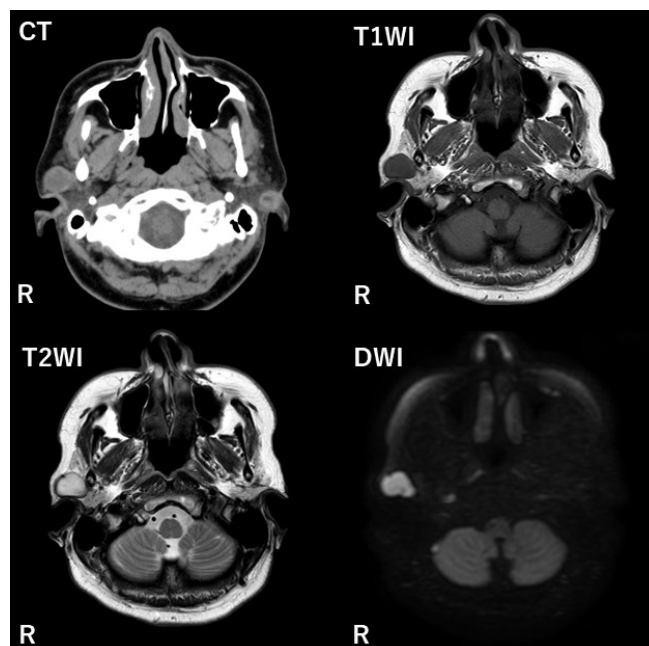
CT imaging showed a well-demarcated, low-density circular mass with a capsule in the right parotid gland. MRI demonstrated a high signal on T2-weighted imaging (T2WI), a low signal on T1-weighted imaging (T1WI), and a high signal on diffusion-weighted imaging (DWI).
